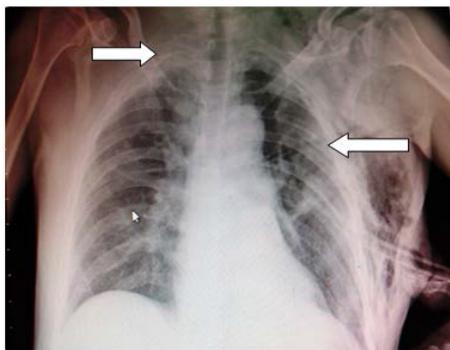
Chest radiograph on admission: shows fracture of the left 2nd 3rd 4th 5th and 6th ribs with left subcutaneous emphysema; and fracture of 1st 2nd and 3rd ribs on right side (arrow).
